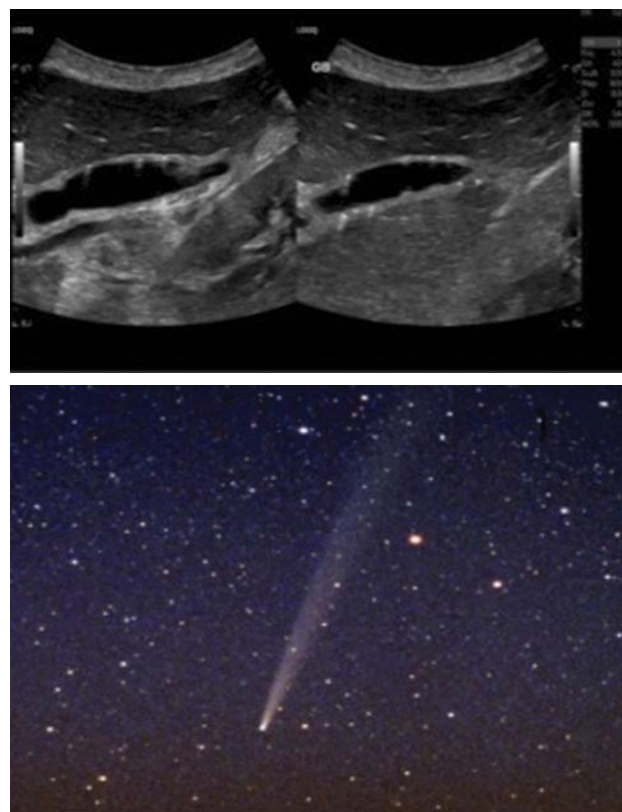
Grey scale ultrasound of gall bladder showing comet tail artifact arising in gall bladder wall consistent with adenomyomatosis.
